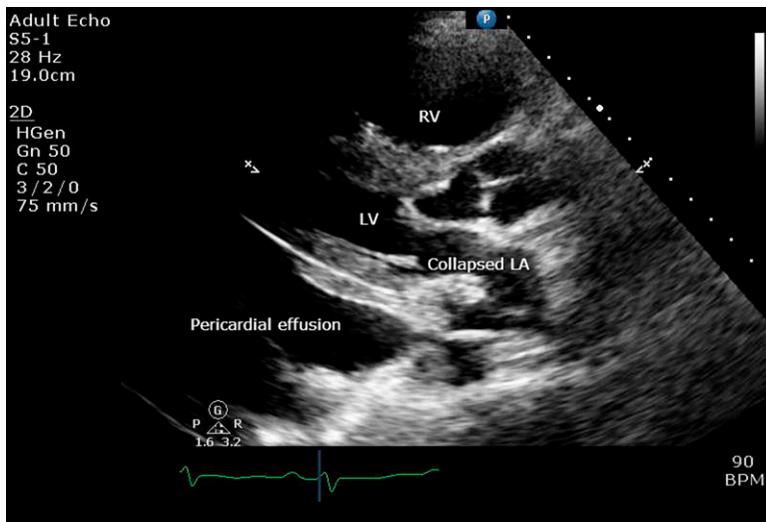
Parasternal long-axis view during ventricular diastole. Note the compression of the left atrium by the pericardial fluid. BPM = beats per minute; LA = left atrium; LV = left ventricle; RV = right ventricle.
